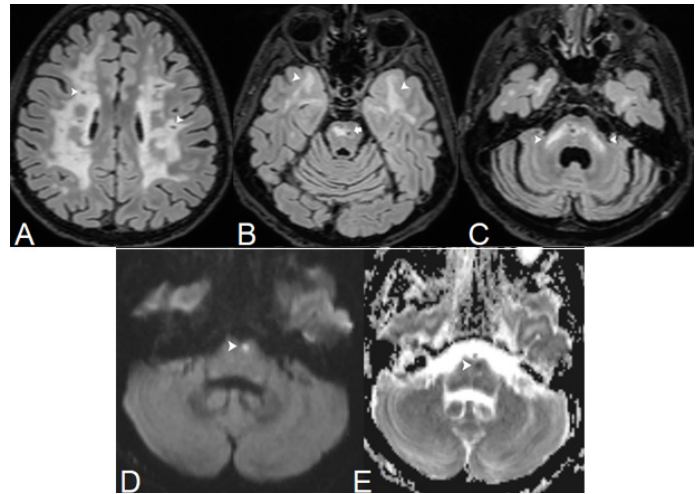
Brain MRI of Case 2. Axial FLAIR images. A. Symmetrical confluent hyperintense signal changes in the periventricular and the subcortical white matter and lacunar infarctions (arrowheads). Subcortical U fibers are spared. B. Hyperintense signal changes in the bilateral anterior temporal lobes (arrowheads) and the pons. There is a lacunar infarction in the pons (arrow). C. Arc-shaped hyperintense lesions from the pons to the middle cerebellar peduncles, the arc sign (arrowheads). Axial D. DWI and E. ADC images show restricted diffusion indicating lacunar infarction in the pons (arrowheads).
